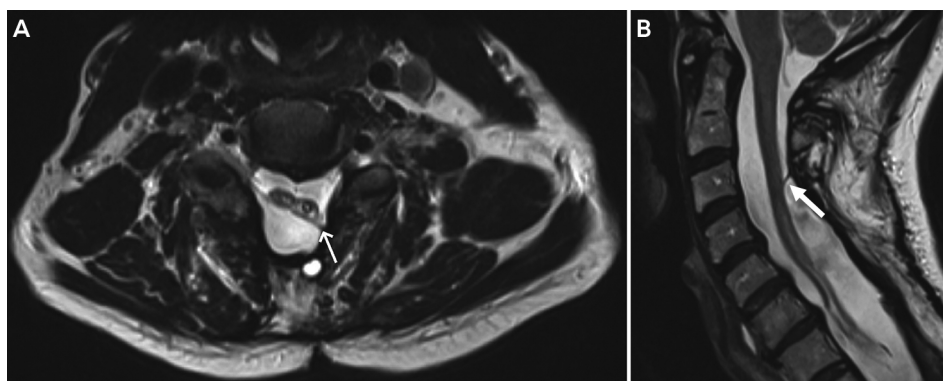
Arachnoiditis with spinal cord tethering. A, Axial T2-weighted MRI of the cervical spine shows tethering of the cervical spinal cord (arrow) from arachnoiditis. B, Sagittal T2-weighted MRI also shows tethering of the cord (arrow) through the arachnoid space.
